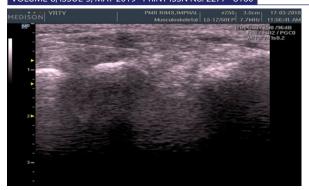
Ultrasound image showing needle position
